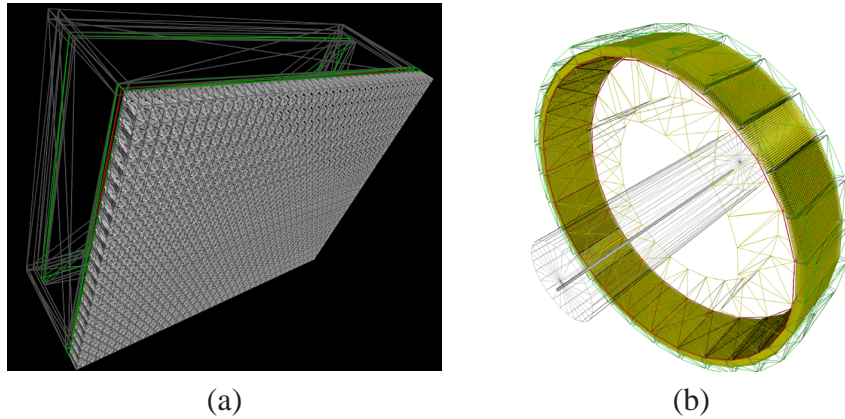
Example scanner types modeled in GATE: (a) SPECT system , (b) PET system.
